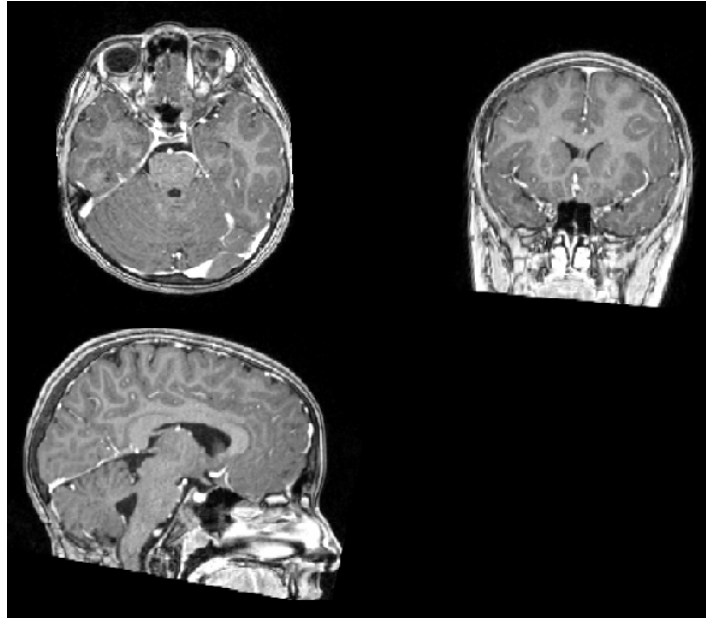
T1-weighted MPR Magnetic Resonance Image of a 10-years old patient after a follow up period from the treatment, in transverse, coronal and sagittal view.
